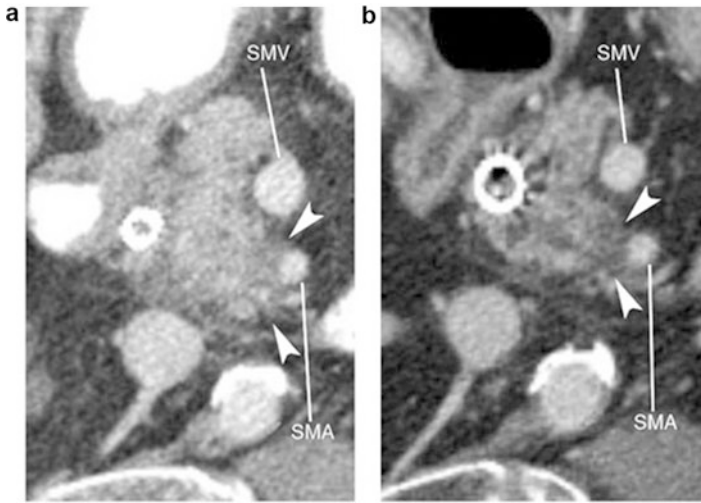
Pre- and post-treatment CT scans of a 78-year-old patient presenting with tumor abutting the SMA. (a) Pretreatment scan shows tumor (white arrowhead) involving the SMA for approximately 180°. Patient's preoperative CA19-9 was 359 U/ml. Patient was treated with gemcitabine and nab-paclitaxel for two cycles and followed by gemcitabine-based chemoradiation (50.4 Gy); (b) after chemotherapy and chemoradiation, despite reduction in the size of the hypodense tumor, arterial abutment was still present though there was a decline in the CA19-9 to 40 U/ml. Approximately 5 months after her initial visit, patient underwent pancreaticoduodenectomy. Pathology revealed a residual infiltrating moderately differentiated adenocarcinoma of the head of the pancreas (2.0 cm), a treatment effect was seen, with 20–30% viable tumor. Proximal gastric, distal duodenal, and retroperitoneal resection margins were negative for tumor (R0 resection), and the tumor was 1.0 cm from the retroperitoneal margin. Seventeen regional lymph nodes were removed and all were negative for micro-metastatic disease. Patient received adjuvant chemotherapy with single agent gemcitabine. The patient is 40 months out from completion of her treatment with no radiographic evidence of local recurrence or metastases
